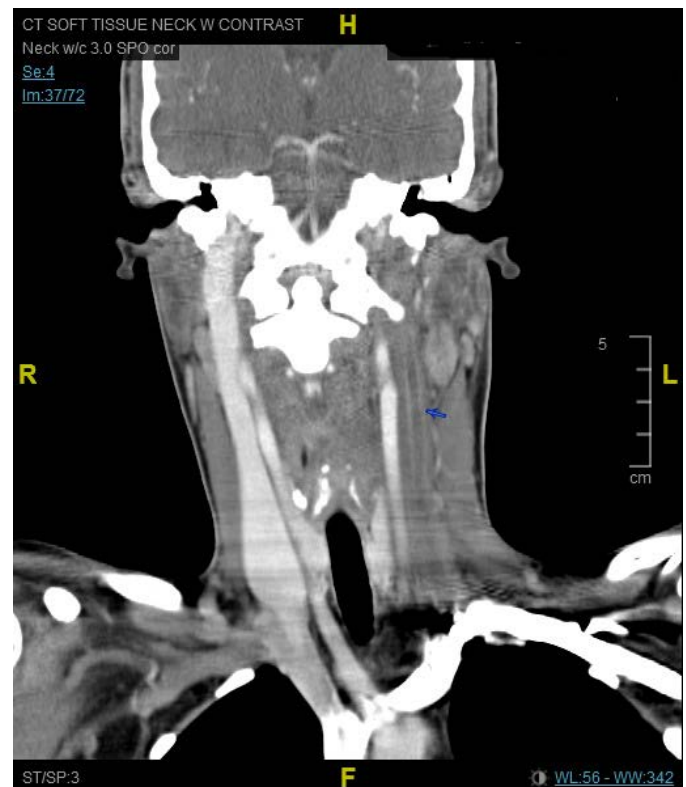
CT scan neck with contrast (coronal). Distended left jugular vein with centrally hypodense filling defect extending throughout the entirety of the jugular vein (arrow).
